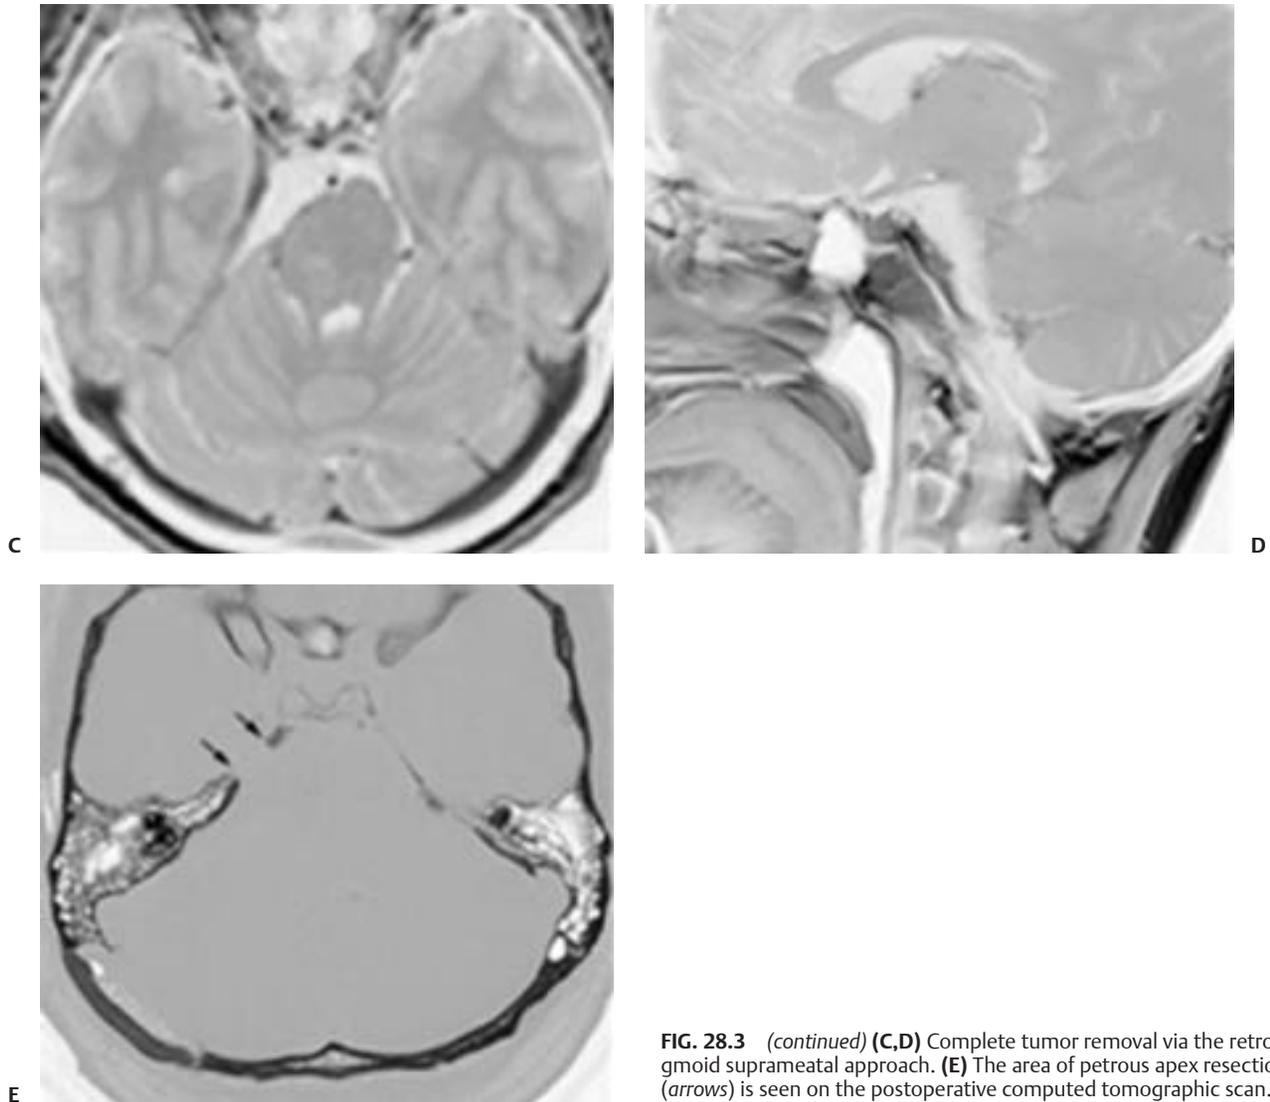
(continued) (C,D) Complete tumor removal via the retrosigmoid suprameatal approach. (E) The area of petrous apex resection (arrows) is seen on the postoperative computed tomographic scan.
